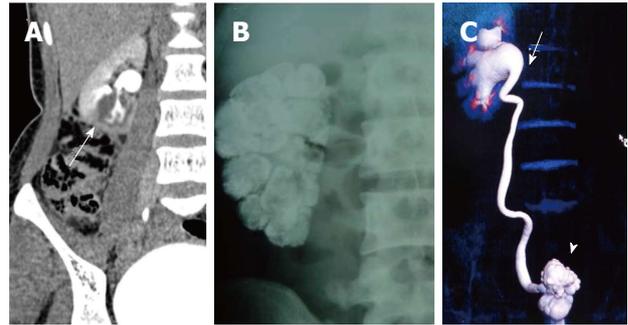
Renal tuberculosis. A: Delayed CECT shows a cavitation at the lower pole of right kidney communicating with the PCS. This finding is fairly typical of GU TB. This adolescent male was a known case of pulmonary tuberculosis; B: Plain abdominal radiograph in a different patient shows diffuse parenchymal calcification of right kidney suggestive endstage autonephrectomy or putty kidney; C: Volume rendered technique image of delayed phase CECT shows a contracted thimble bladder (arrowhead), hiked up right pelvis (arrow) and hydronephrosis. This patient had acid fast bacilli cultured from urine. PCS: Pelvicalyceal system; CECT: Contrast-enhanced computed tomography; TB: Tuberculosis.
